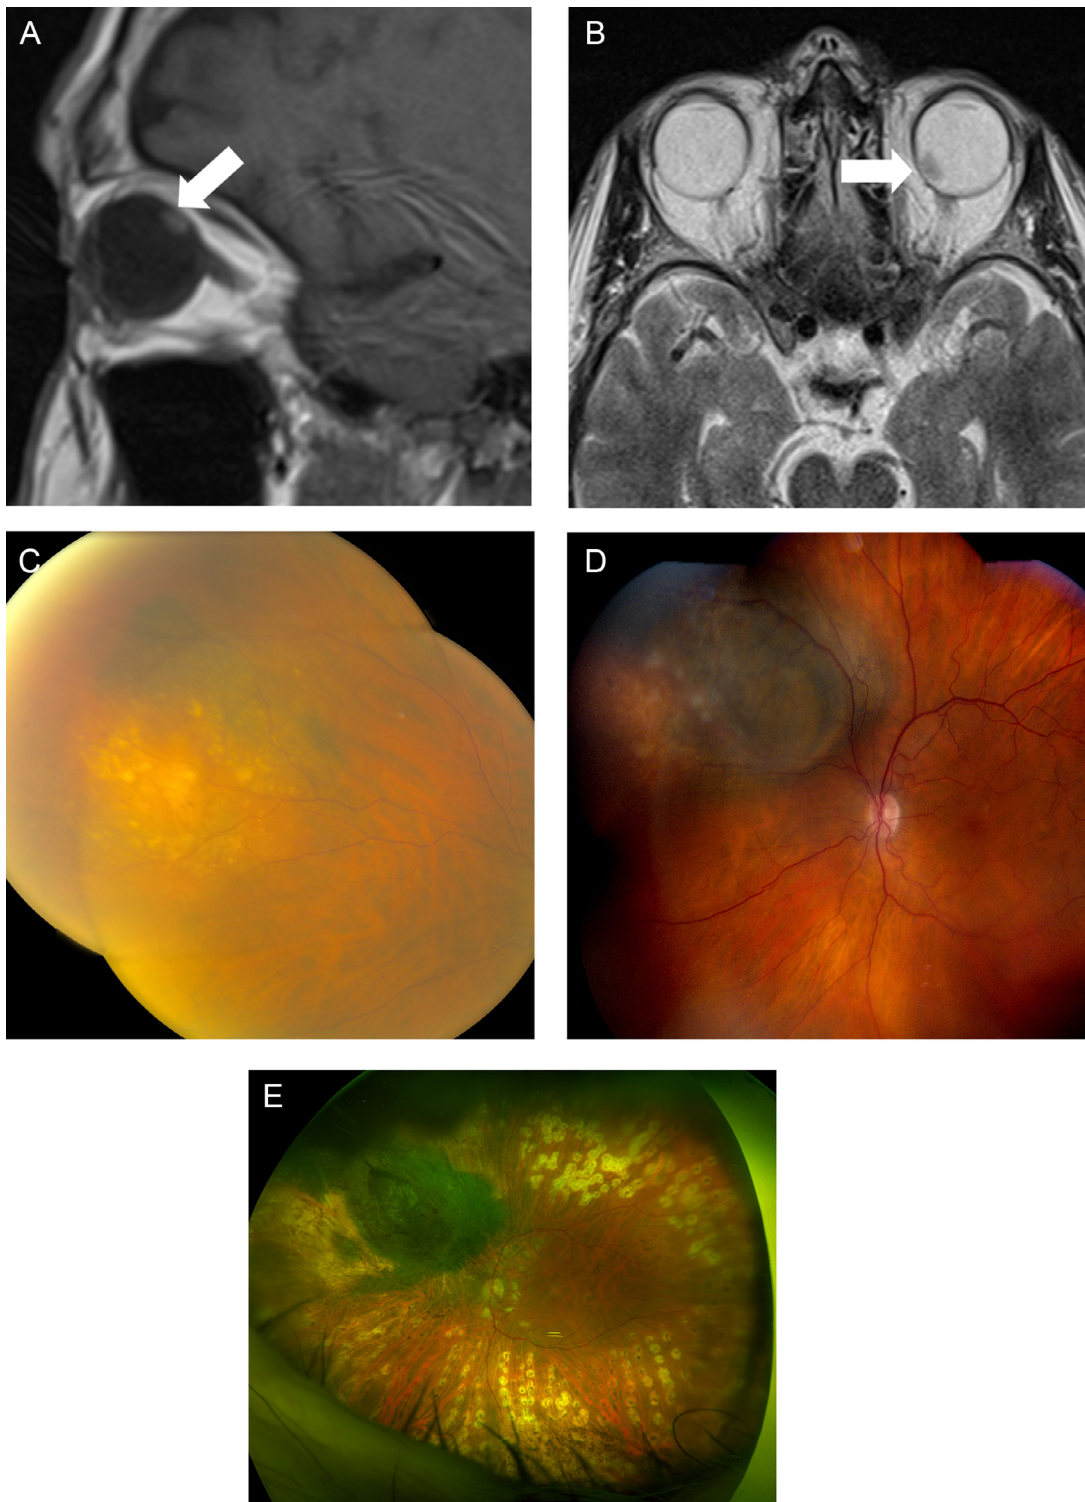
Patient 1. (A-B) Sagittal T1 weighted image (A) and axial T2 weighted image (B) from brain MRI for an unrelated condition demonstrated an incidental small T1 hyperintense and T2 hypointense mass centered at the superomedial aspect of the left posterior globe (arrows). There was no evidence of extraocular extension or optic nerve involvement. (C) Four years prior to presentation, a choroidal nevus was noted in the superonasal quadrant. (D) At presentation, an elevated, lightly pigmented choroidal lesion was identified in the same location. (E) Eighteen months after completing PBRT, he developed radiation retinopathy and vitreous hemorrhage requiring vitrectomy surgery and laser delivery to the peripheral retina.
